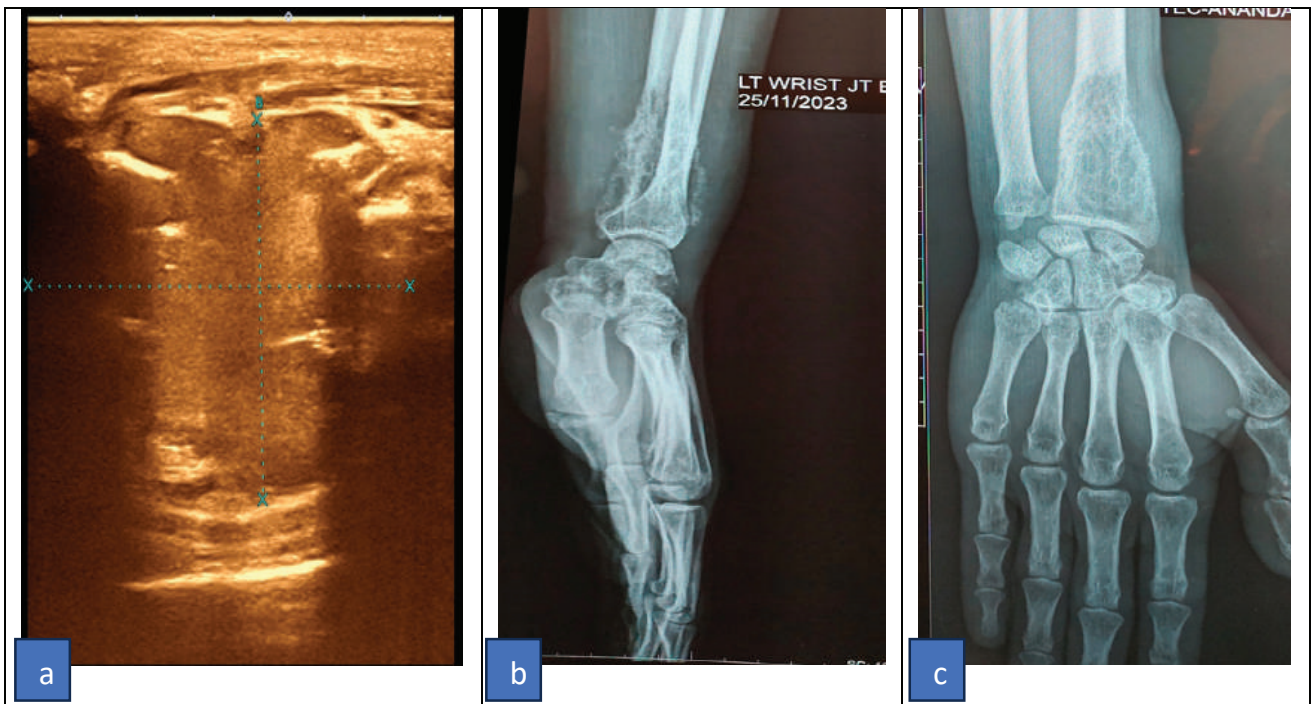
(a) HRUS of hand image showing poorly demarcated, hypoechoic, solid mass lesion in the distal end of left radius (a), Xray of left wrist joint lateral (b) and AP (c) view showing expansile lytic lesion causing destruction of cortex and having few periosteal reactions, abutting the articular surface at distal end of left radius.
